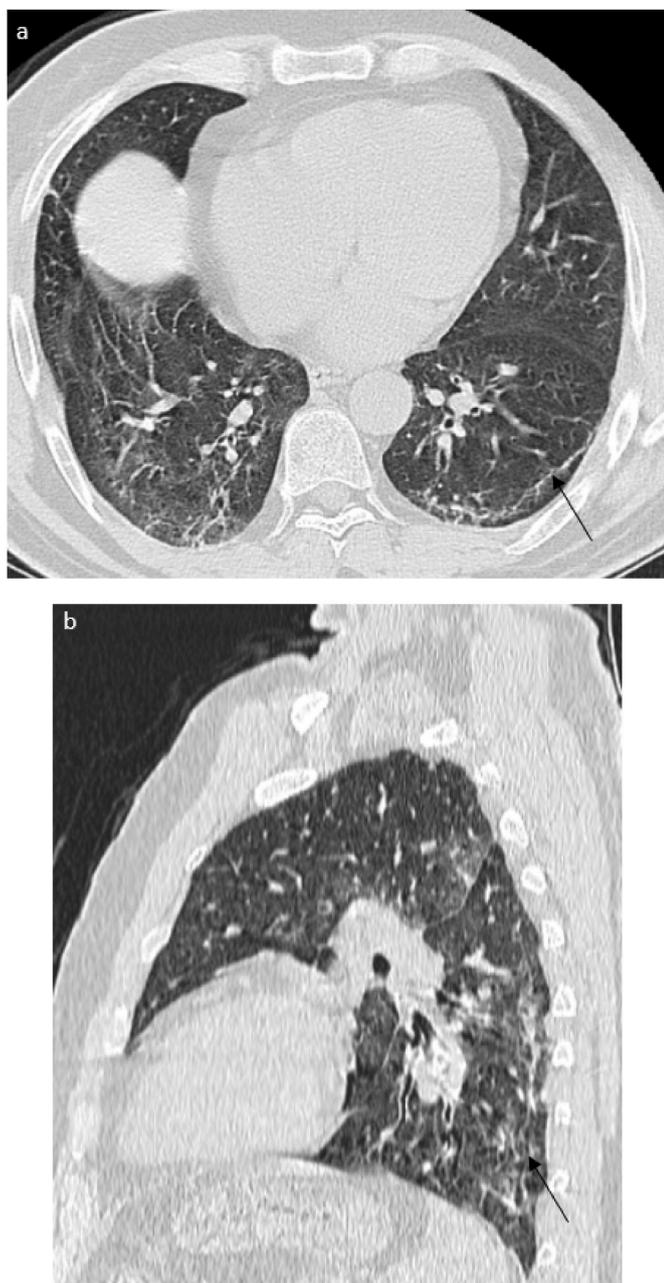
A 64-year-old man's 12 months follow-up non-enhanced chest CT axial (a) and sagittal (b) images showing residual curvilinear sub-pleural opacities (Black arrow) involving peripheral lung bases.
